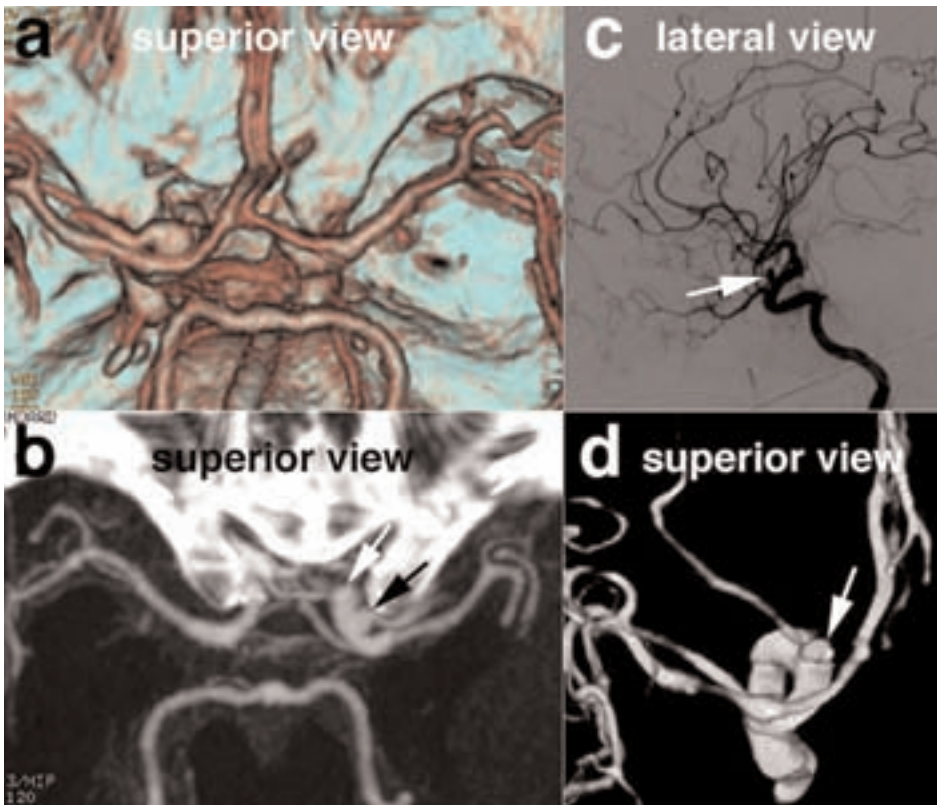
63-year-old male patient. On CTA (a), especially on MIP (b), left deep middle vein (black arrow) creates confusing pattern. Aneurysm was identified in its correct location by one of the reviewers only, whereas the other reviewer confused it with left deep middle vein and described it as paraclinoid. DSA (including 3D DSA) (c,d) demonstrates 3-mm aneurysm located at origin of left ophthalmic artery (white arrows), with sac/neck ratio in range of 1 to 1.4.
